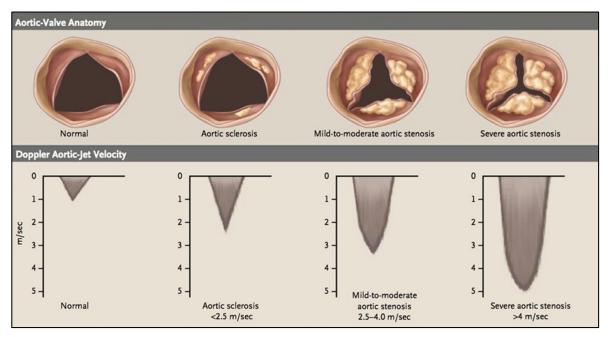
Disease progression in calcific aortic stenosis, showing changes in leaflet opening in systole and Doppler velocities¹⁴
